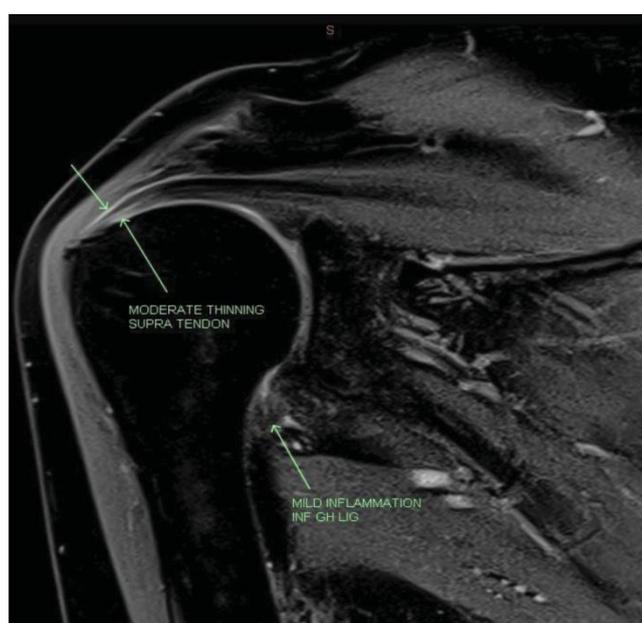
post-treatment MRI demonstrating complete healing of the supraspinatus tear
